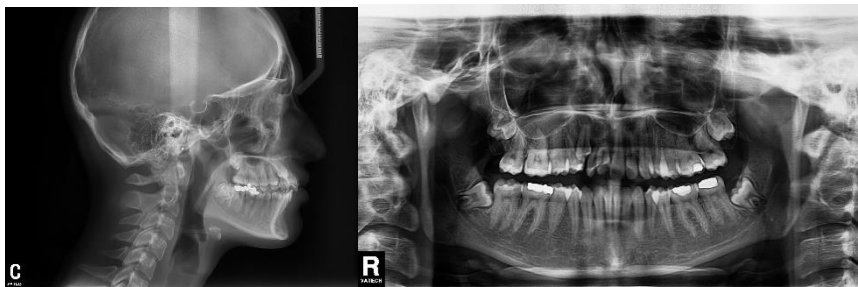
Initial lateral cephalometric radiograph, panoramic radiograph.
